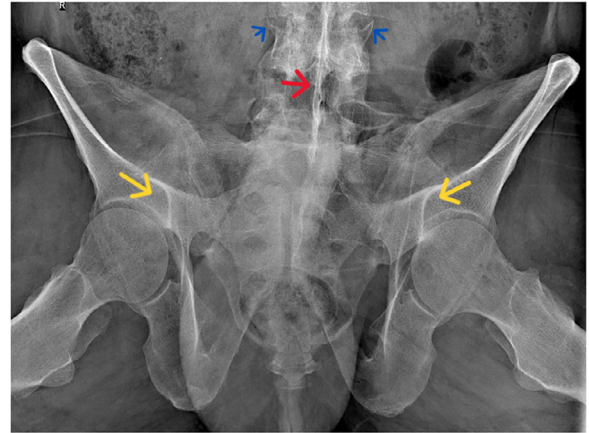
Posterior X-ray of the sacroiliac joint showing bilateral sacroiliac ankylosis (yellow arrow), the dagger sign (red arrow) and lumbar vertebrae osteophytes (blue arrow).
